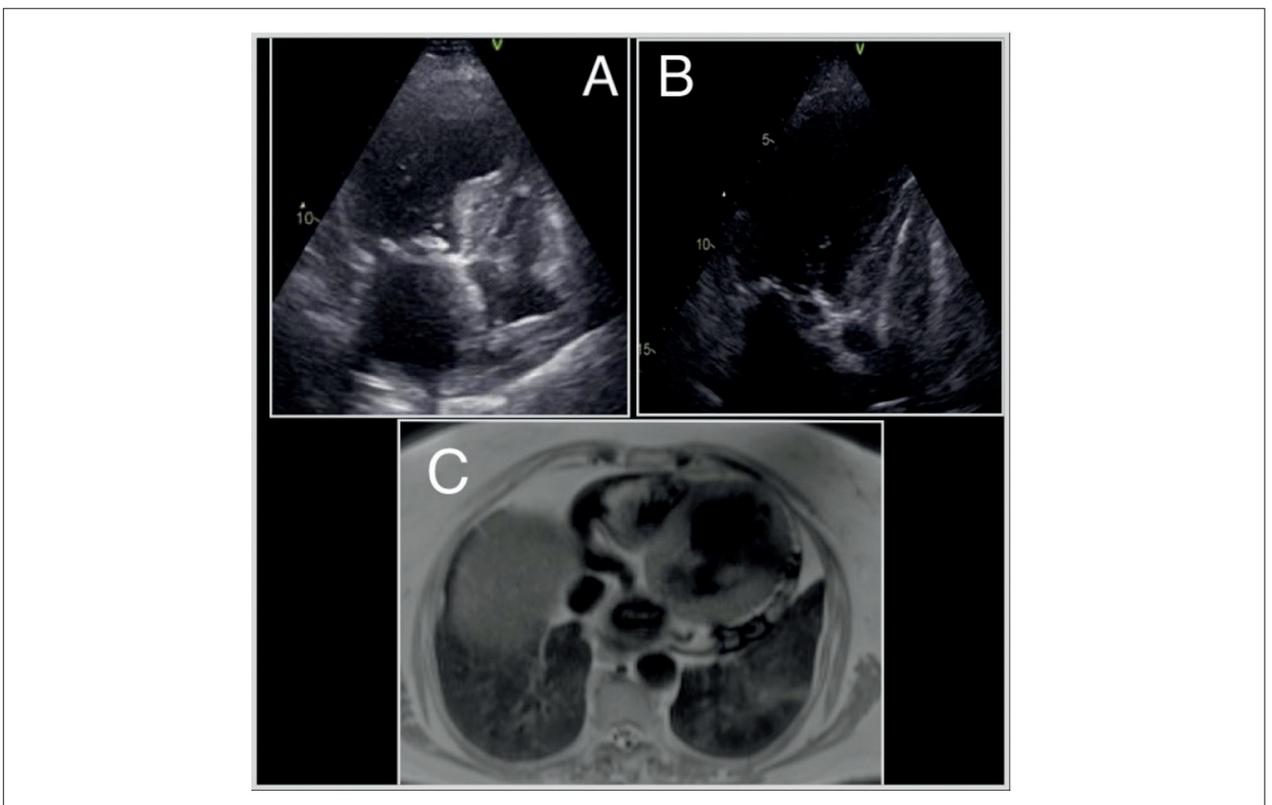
A-B: Transthoracic echocardiogram demonstrating left ventricular apical ballooning and lead image in the right chambers on apical four-chamber view C: Apical ballooning on cardiac MRI.
